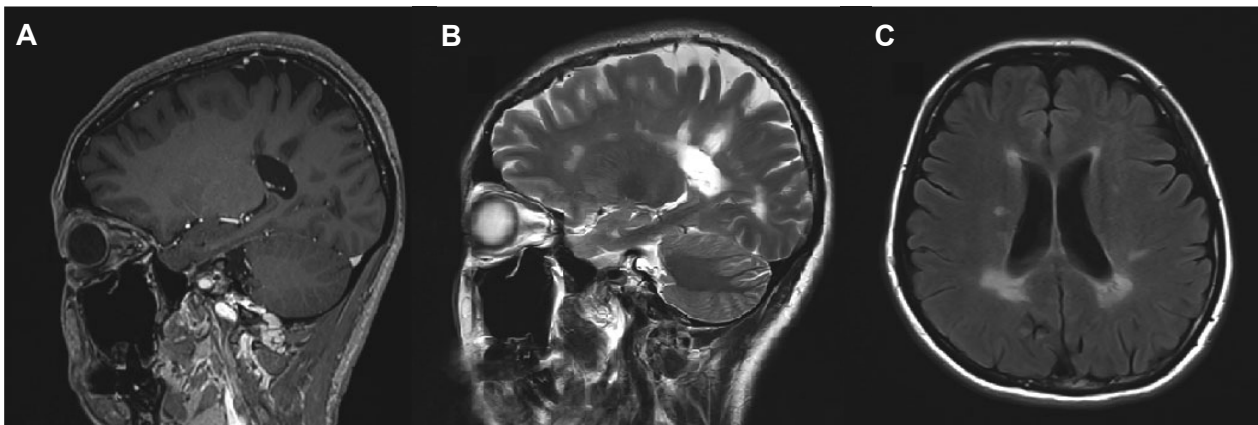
Dawson-finger sign of Multiple Sclerosis: Multiple subcortical and periventricular lesion arranged in a perpendicular fashion. (A) Hypointense and non-enhancing lesion under T1-weighted sagittal MRI. (B) Residual focal edema under T2-FLAIR axial MRI. (C) Hyperintense under T2-FLAIR axial MRI.
